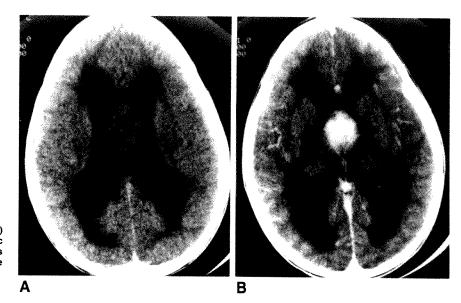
Nonenhanced (A) and enhanced (B) axial CT scans show isodense enhancing pilocytic astrocytoma arising from septum pellucidum. This sharply demarcated round tumor was proved to be subependymal at surgery.
